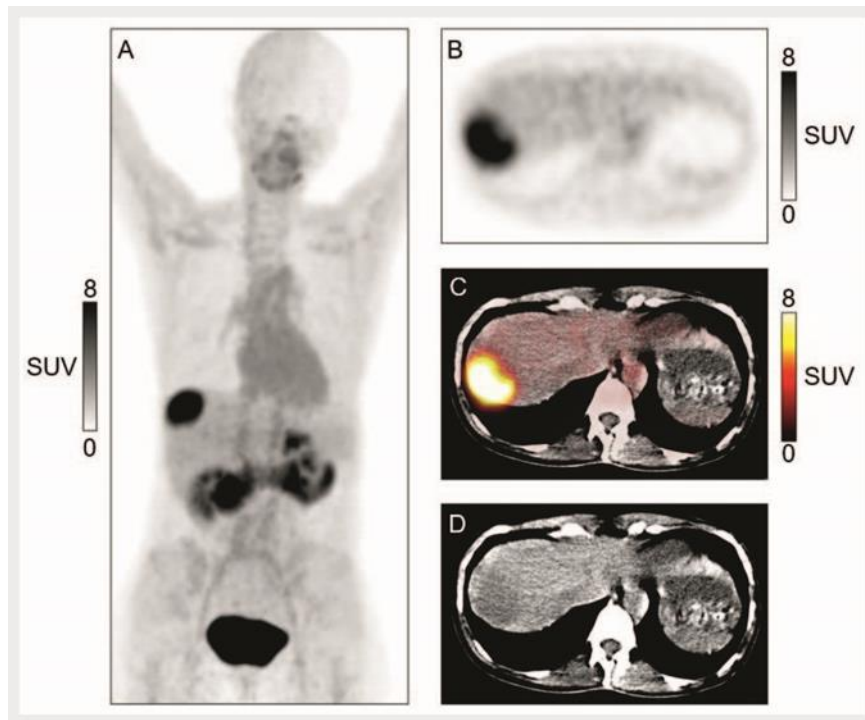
FAPi-PET/CT. Intensive tracer uptake in liver segment 8. In low-dose CT-technique without contrast medium there is only a faint hypodense lesion.
